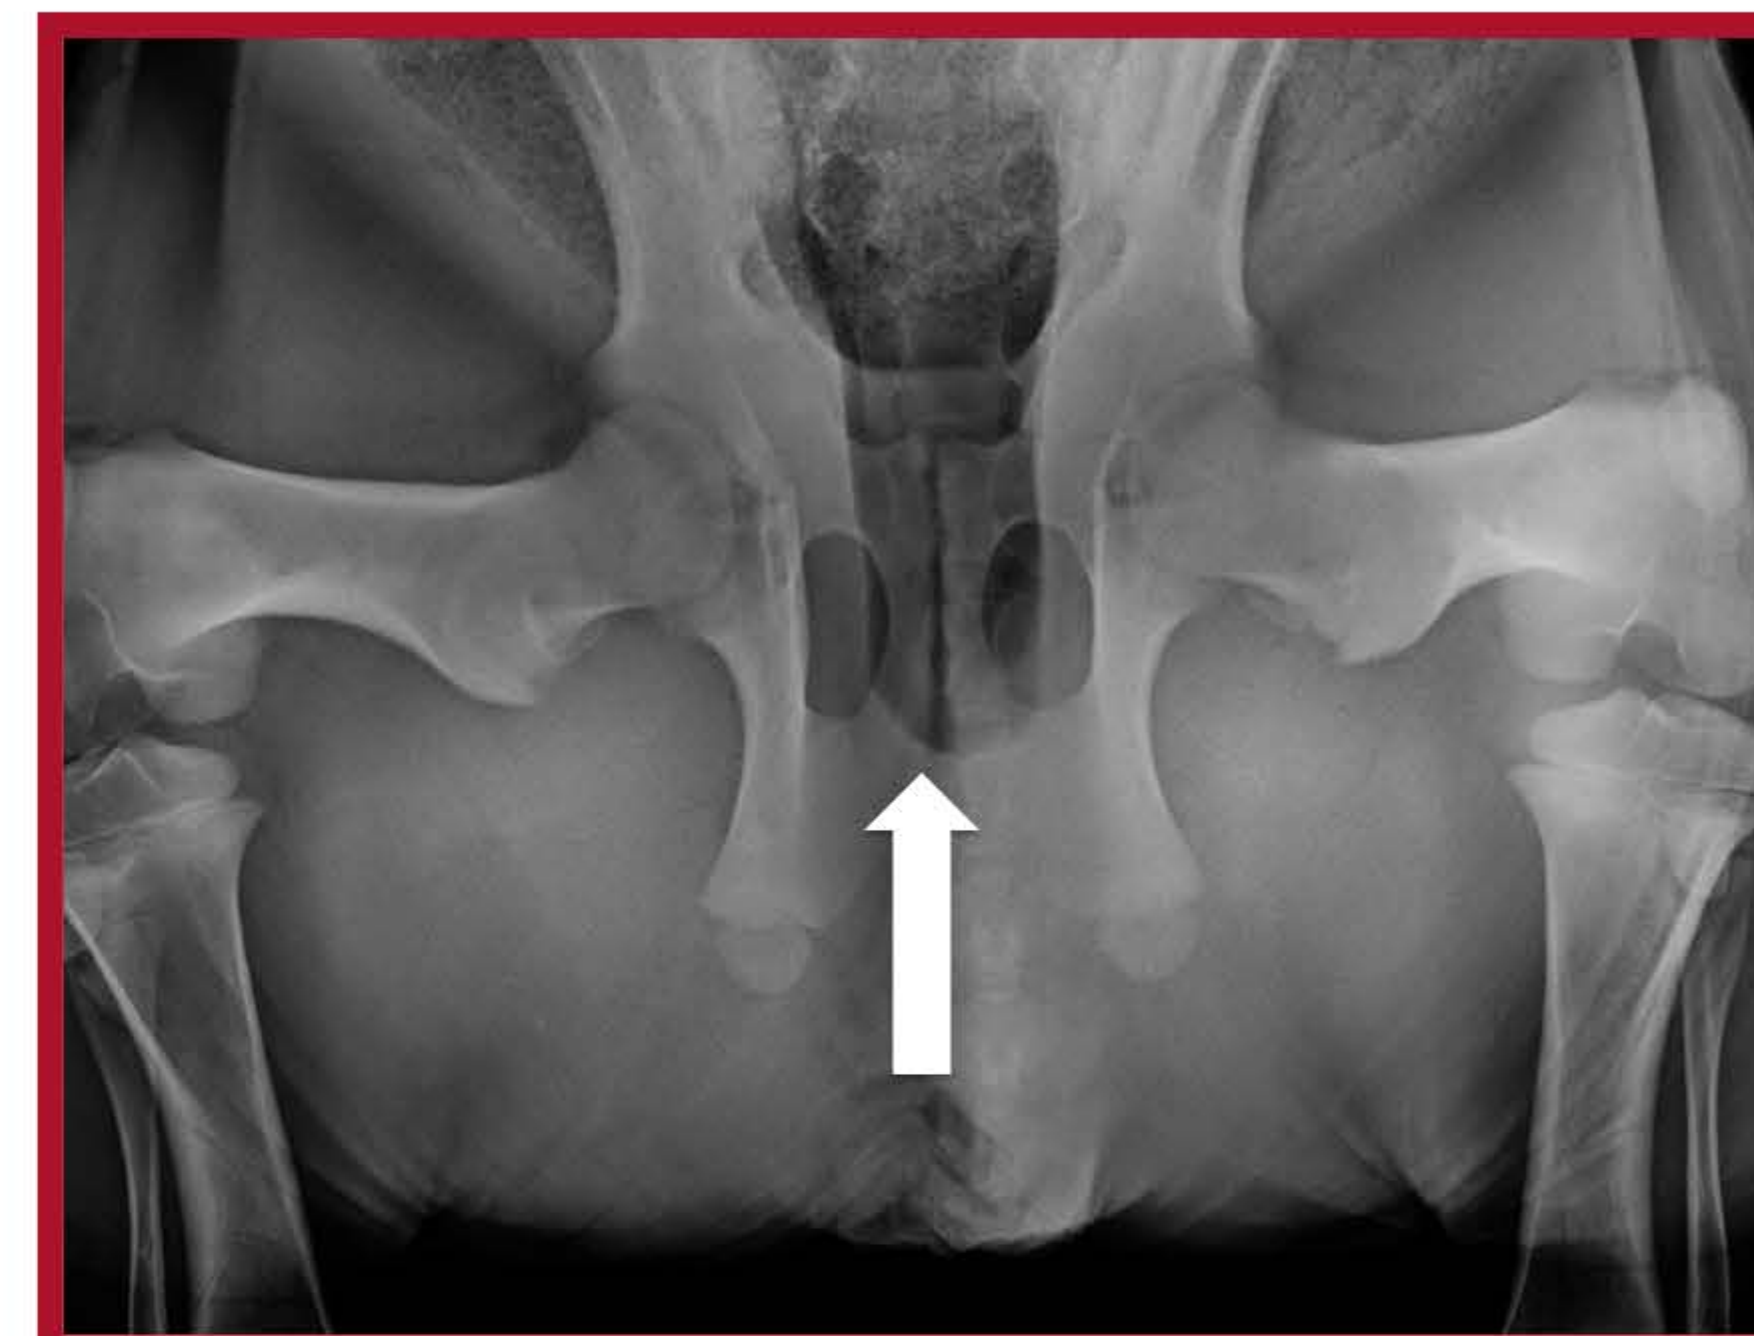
VD radiograph view of pelvic area showing that no gas was detected from mid-pelvis to the rectum (arrow).
